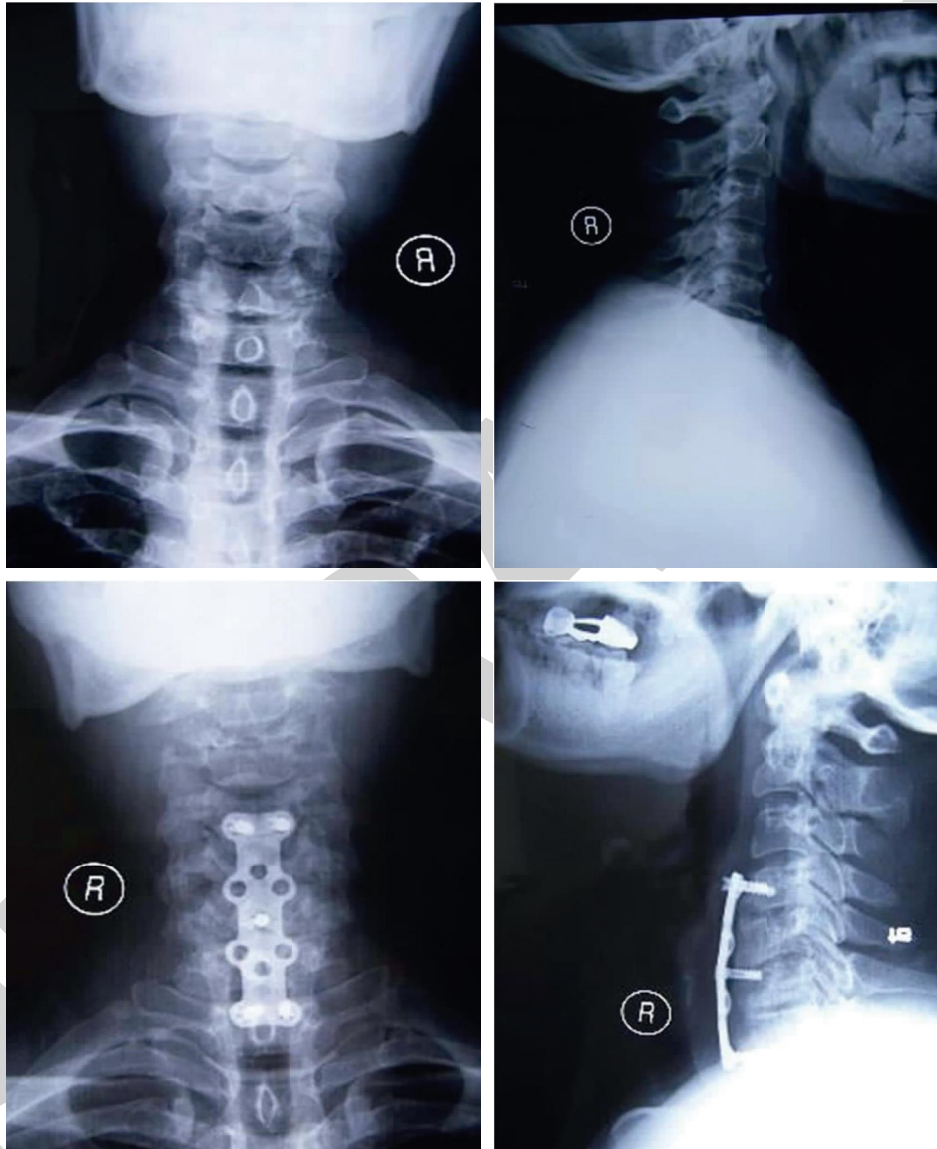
Preoperative and postoperative anteroposterior and lateral radiographs.
